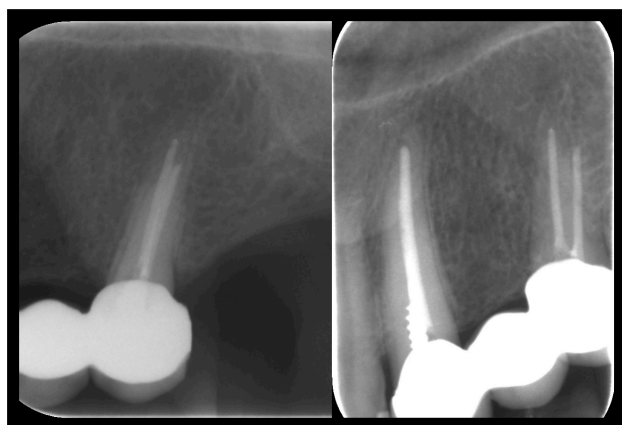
Preoperative radiographs, 16. Nov 2011
